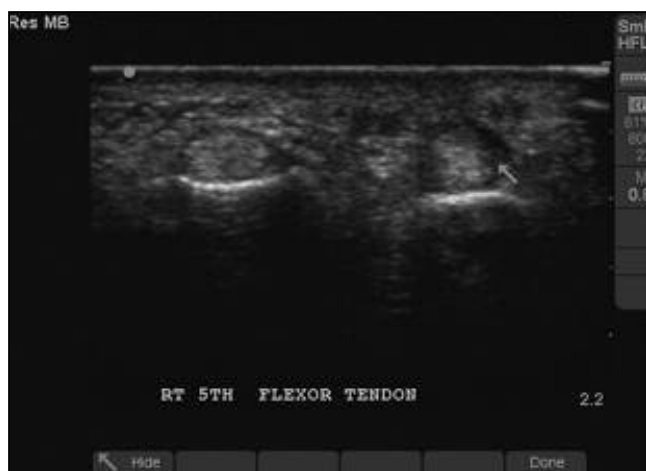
Ultrasound image of an affected tendon in the hand of a 64-year-old woman with Dupuytren contracture 8 weeks after completion of dry needling treatment. The image reveals a reduction in fibrous nodularity. The arrow points to a small artifact of initial nodule. Image was taken with a 13.0-MHz high-frequency linear transducer (Micromaxx; Sonosite Inc, Bothell, Washington).
